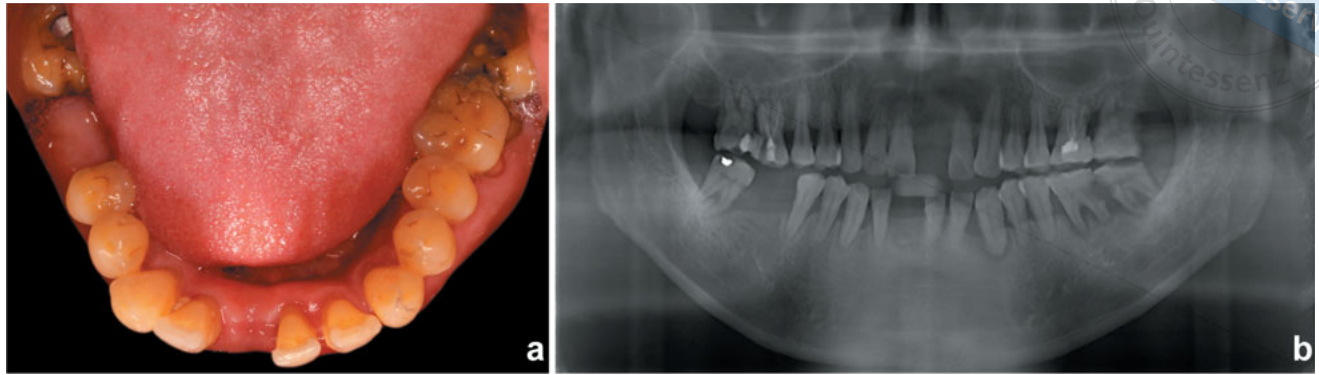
Pretreatment photographs: (a) intraoral view of the mandible and (b) panoramic radiograph of the initial dental status.
